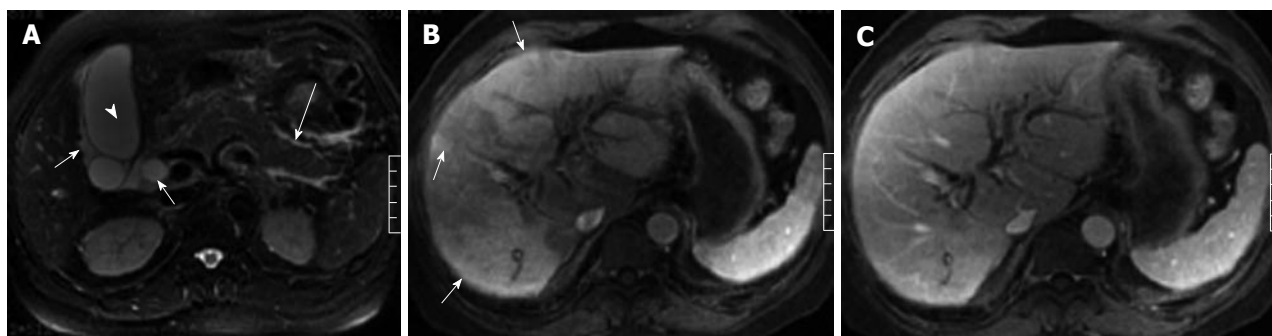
A 65-year-old man with acute pancreatitis combined with cholecystitis as well as common bile duct and intrahepatic bile duct dilatation. Fast recovery fast spin-echo T2-weighted image (A) shows gallbladder distention (arrowhead), perigallbladder fluid (short arrow), common bile duct dilatation (short arrow), and peripancreatic strand hyperintensity signal (long arrow). Patch- or wedge-shaped hepatic abnormal perfusion is found in the left and right lobes of the liver on the artery phase images (B, arrow) and returns to normal on the venous phase images (C).
